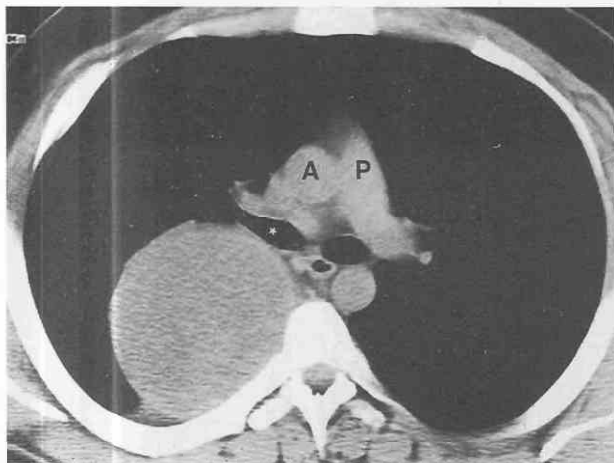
Schwannoma. CT shows a large, homogeneous, paraspinal mass. The round shape is typical of a peripheral nerve tumor. A, aorta; P, pulmonary artery. The asterisk indicates the right main bronchus.
